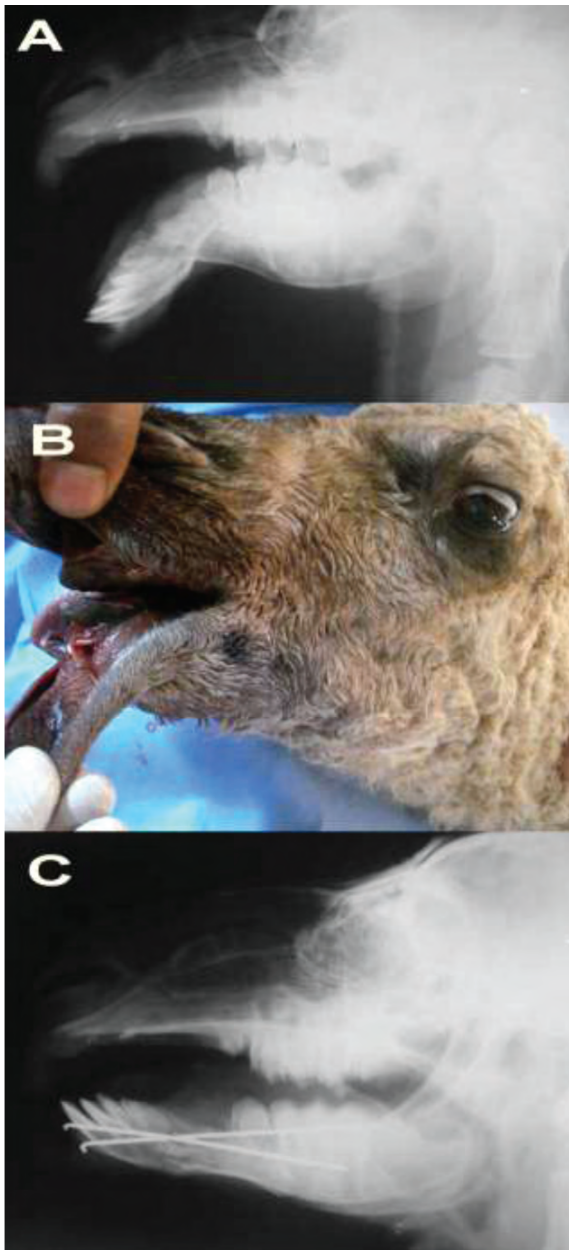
Lateral radiographs of mandibular fracture in a 15-day-old camel (A) and after fixation by 2 Steinmann pins (C), and a photo of the same case after treatment (B).
